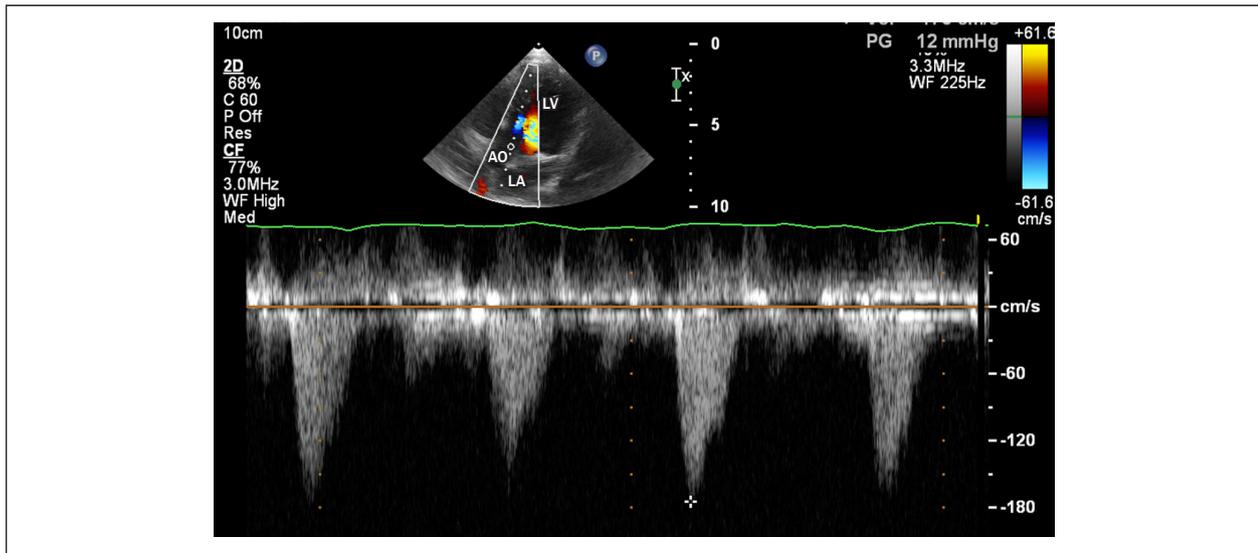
Apical five-chamber view, demonstrating a reduction in the left ventricular outflow tract gradient on color Doppler (12 mmHg) after myectomy. LV: left ventricle; LA: left atrium; AO: aorta.
